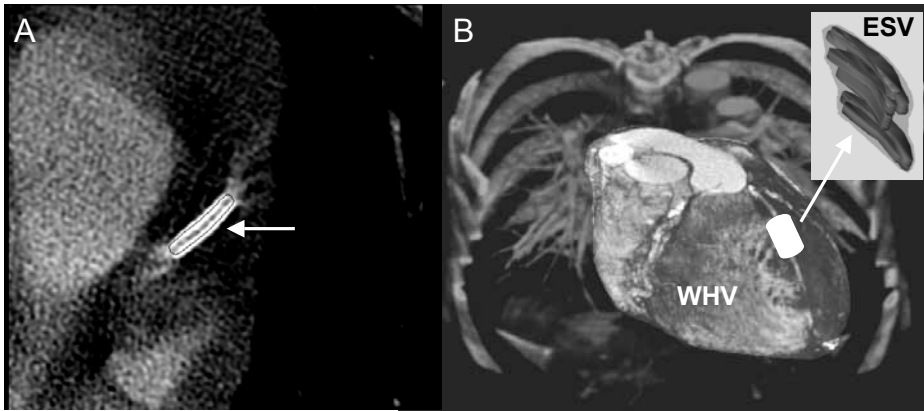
(a) Multislice CT image of a left anterior descending coronary artery stent contoured in black (arrow). (b) Whole heart volume (WHV) and volume encompassing all measured 3D positions (ESV) of a left anterior descending coronary artery stent during the cardiac cycle.
